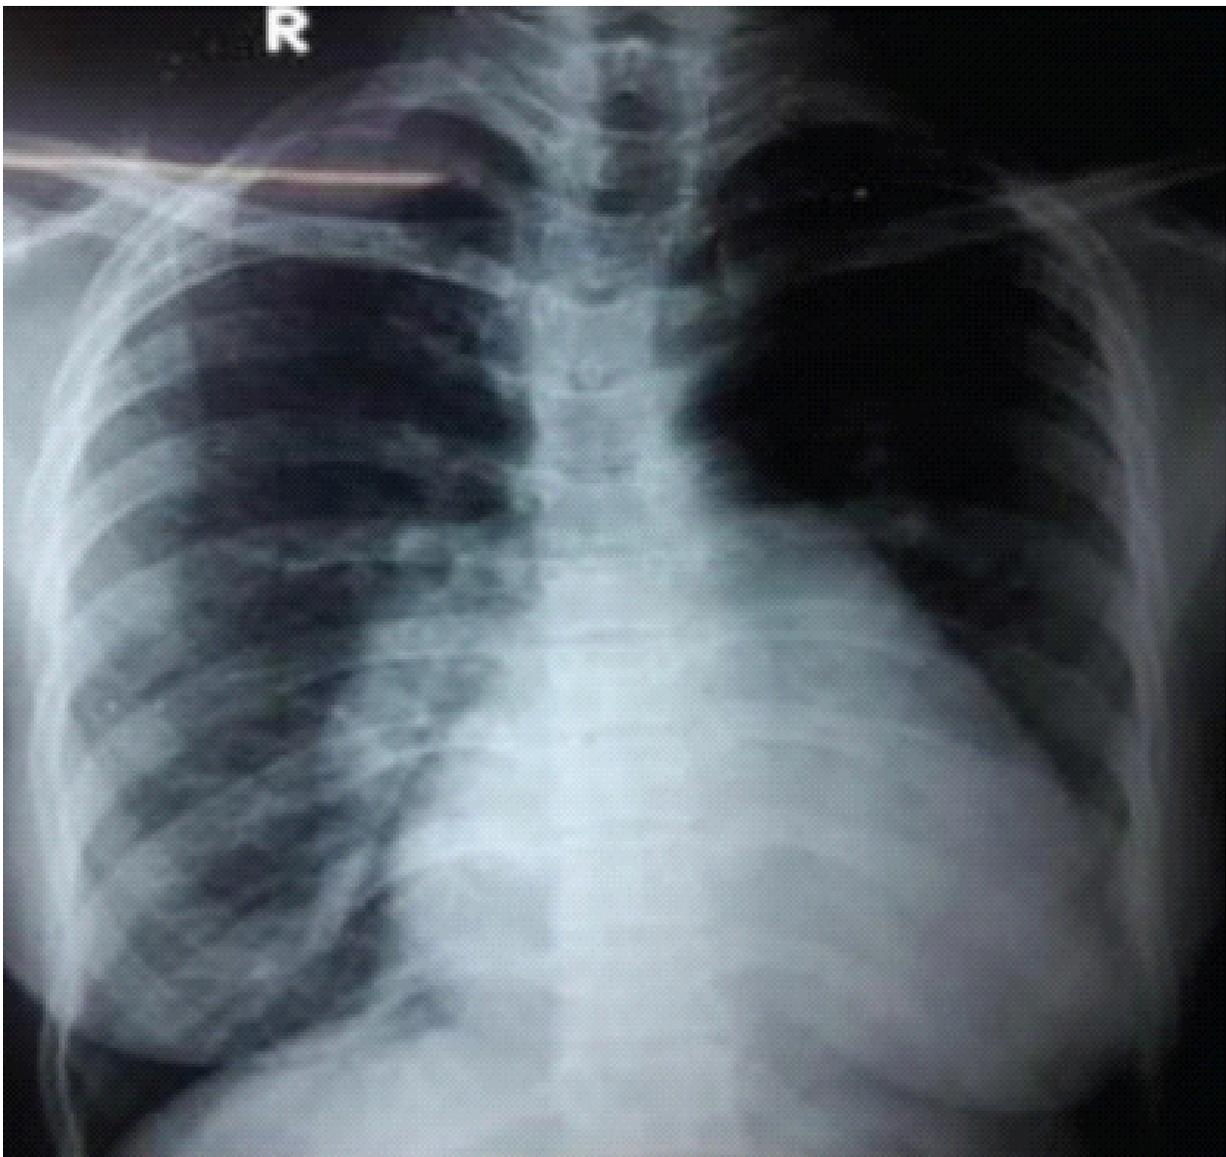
Chest X-ray showed cardiomegaly with RV type apex, dilated right pulmonary artery.
